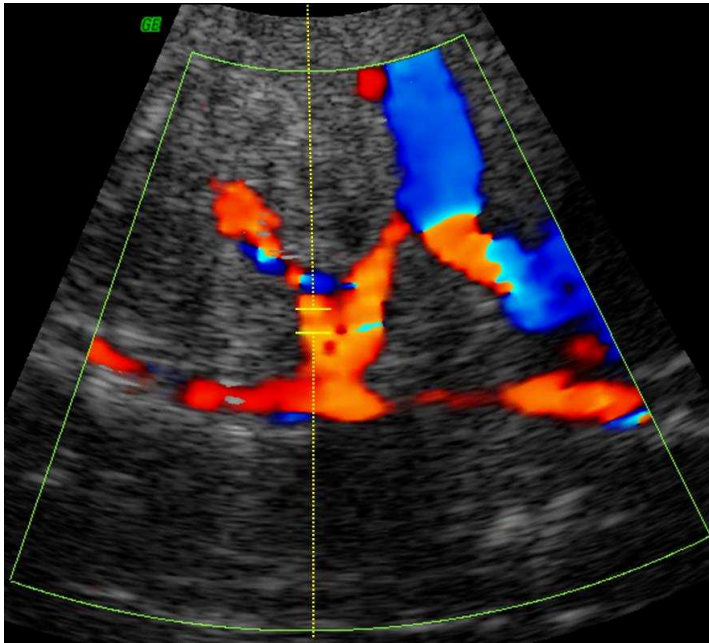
Colour Doppler image of the superior mesenteric artery. The Doppler gate is placed over the proximal part of the vessel (gestational age 38 weeks).
